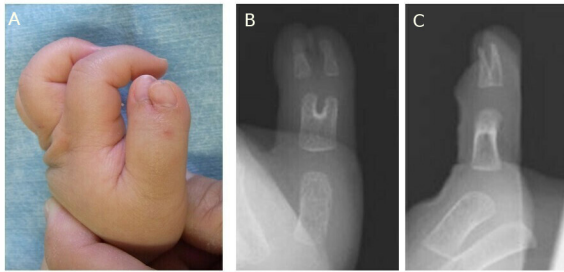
Preoperative findings. (A) Preoperative appearance of the left thumb. (B and C) Preoperative radiograph of the left thumb.
